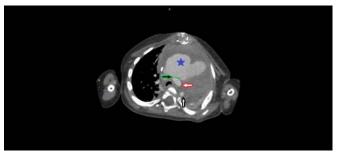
CT imaging of thepatient with an aortic pseudoaneurysm. The green line and arrow delineate the neck of the pseudoaneurysm. The blue star highlights the lumen of the pseudoaneurysm sac. The red arrow indicates the ascending aorta, while the black arrow denotes the descending aorta.
